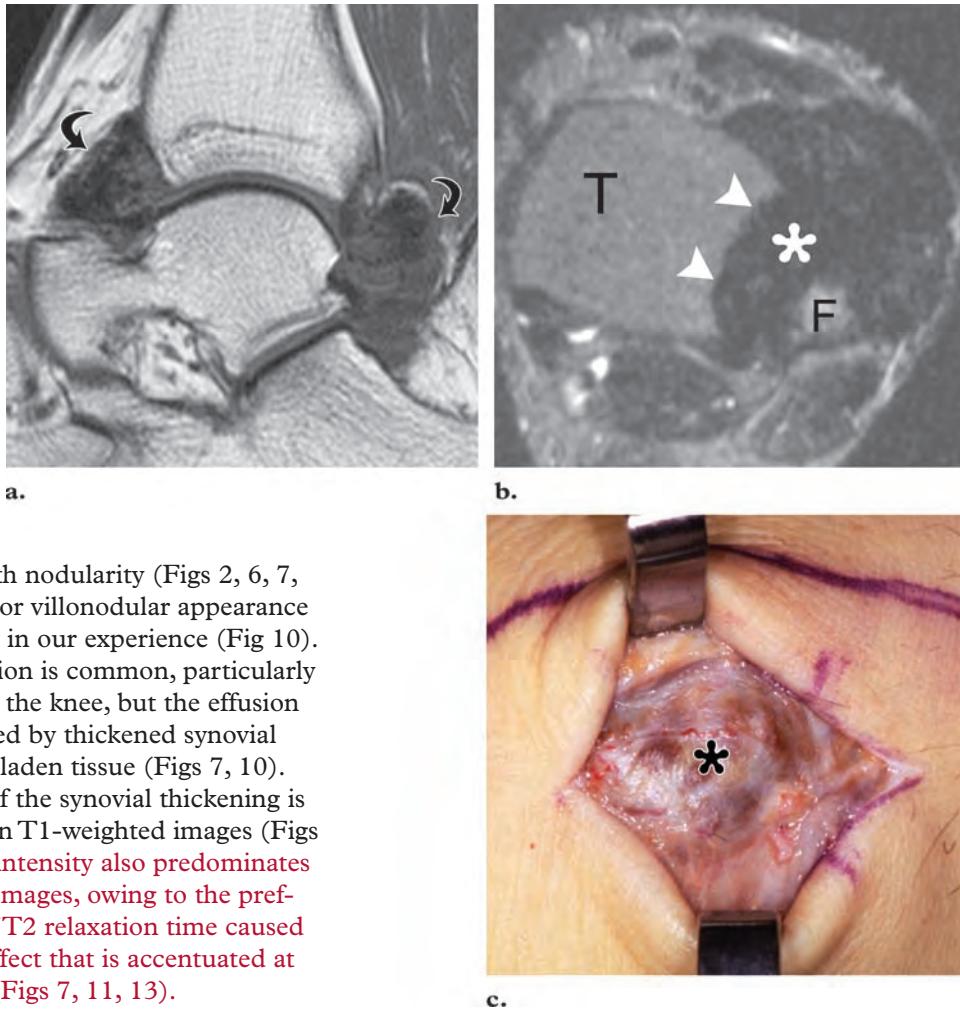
Diffuse intraarticular PVNS of the ankle in a 43-year-old man with pain and a soft-tissue mass. (a, b) Sagittal T1-weighted (600/20) (a) and axial T2-weighted (4830/90) (b) MR images show involvement of the anterior and posterior recesses of the ankle (arrows in a), syndesmotic extension (* in b), and osseous erosion (arrowheads in b). The mass has intermediate signal intensity with T1-weighting and predominantly low signal intensity with T2-weighting. F = fibula, T = tibia. (c) Intraoperative photograph shows the syndesmotic component (*) with prominent brownish areas from hemosiderin deposition.
